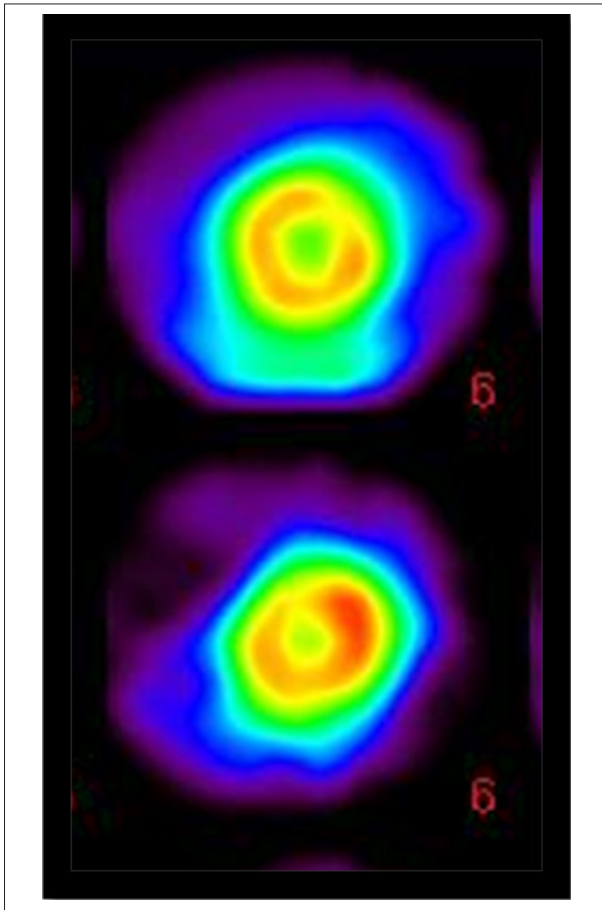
Myocardial scintigraphy with 2-methoxy isobutyl isonitrile -99mTc (sestamibi-99mTc) using protocol (rest-stress), with a 25 mCi dose in each step. The scintigraphic images reveal hypoperfusion in anteroapical and lateral-apical segments of the left ventricle in the post-stress images, with complete improvement of the uptake in relation to the rest images.
